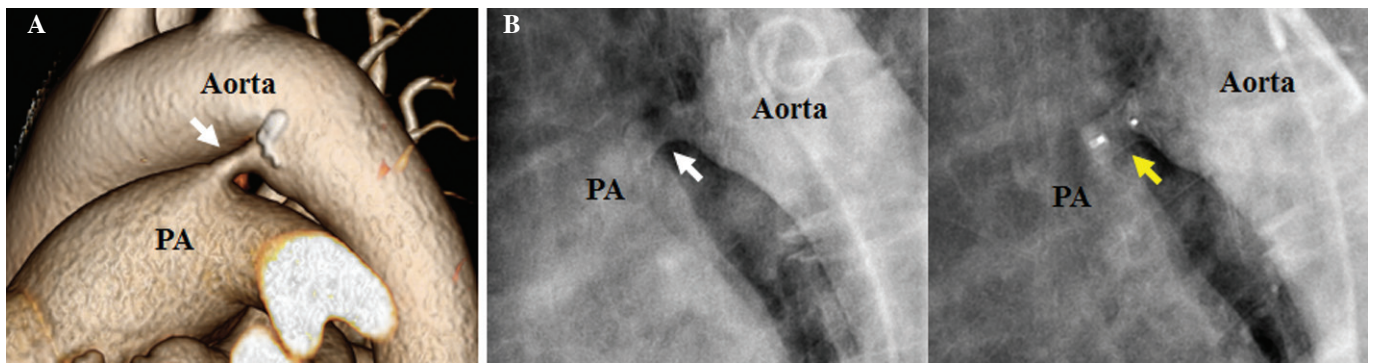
Images demonstrating PDA (white arrow) and PDA closure (yellow arrow) in the present patient. (A) Computed tomography three-dimensional reconstruction of a PDA. (B) Aortography of PDA (left) and percutaneous deployment of Amplatzer ductal occluder on PDA (right) PDA, patent ductus arteriosus; PA, pulmonary artery.
